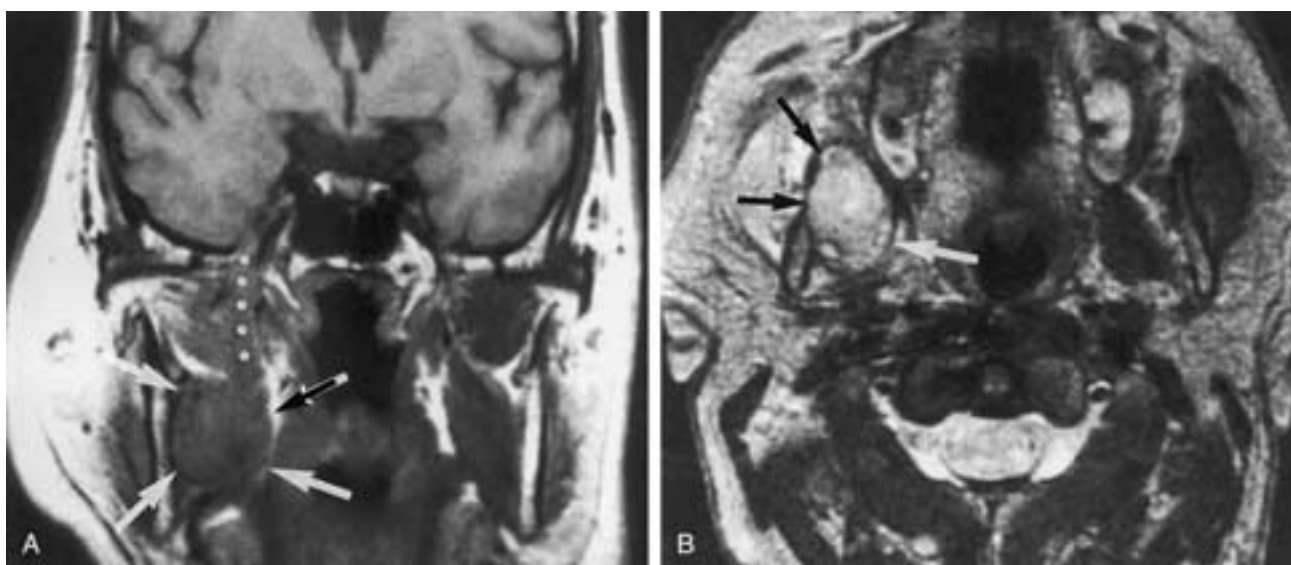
Malignant schwannoma of the right mandibular nerve. A, Coronal T1-weighted MR image demonstrates a mass centered within the right medial pterygoid muscle (*arrows*), extending along the masticator nerve through the foramen ovale and into the cavernous sinus (*dots*). B, Axial T2-weighted MR image demonstrates that the mass is hyperintense to muscle on B (*arrows*).
